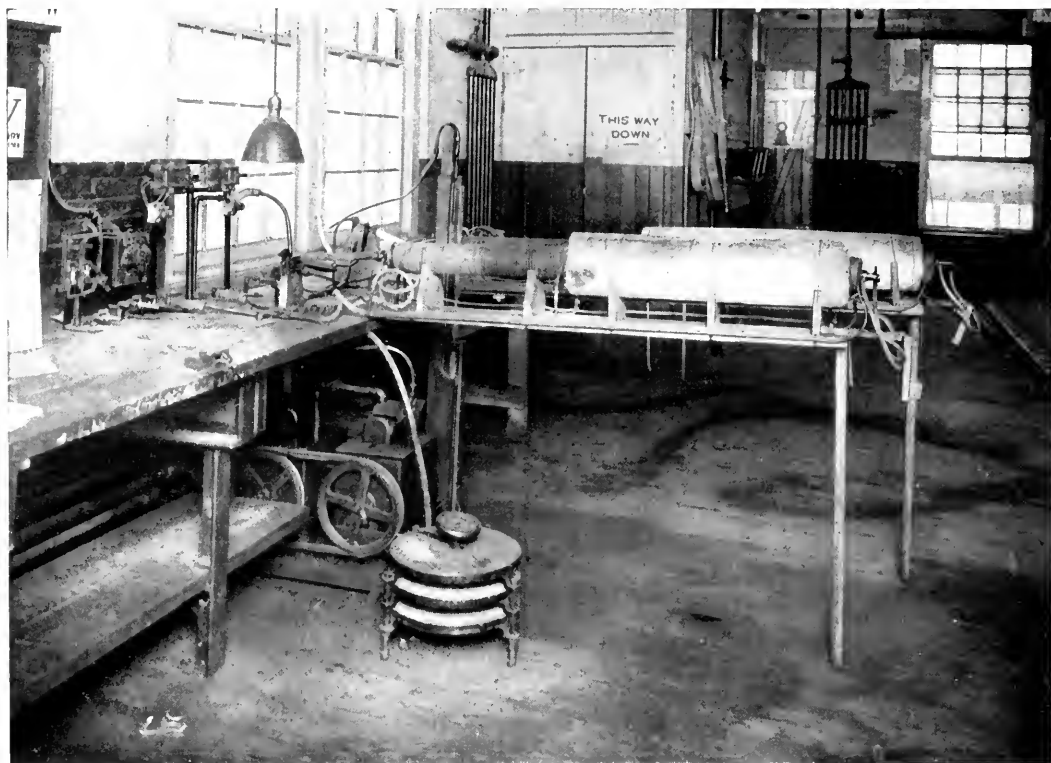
VACUUM FURNACE USED FOR FIRING METAL PARTS OF X-RAY TUBES.
